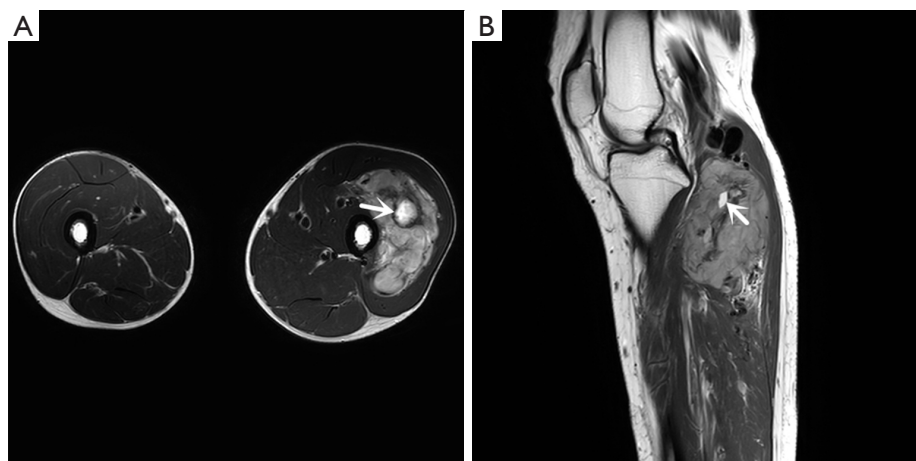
The axial (A) and sagittal (B) T1-weighted images of 3.0-T MRI scanner reveal the high signal intensity mass relative to muscle with internal hemorrhage (arrows). MRI, magnetic resonance imaging.
